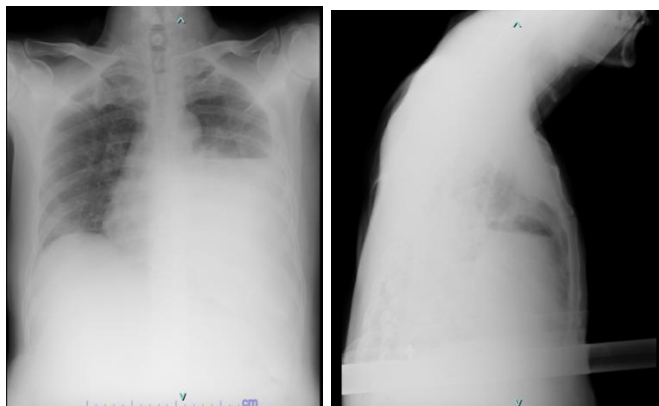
X-ray AP view (left) and lateral view (right) 3 days after empirical antibiotic showed no improvement
